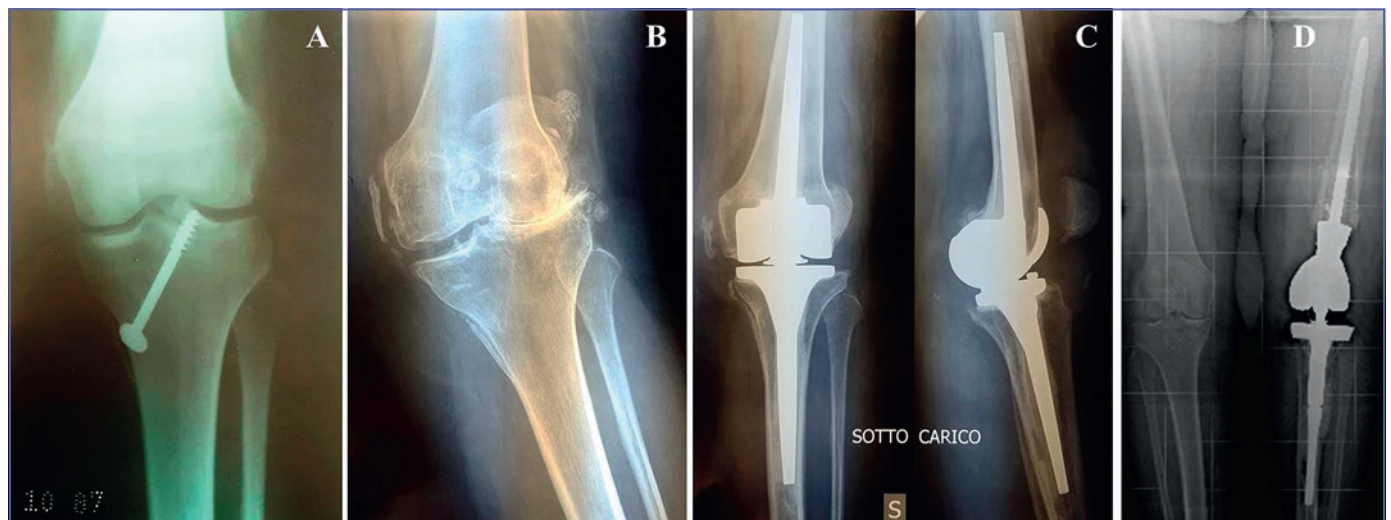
x-ray of previous surgeries. A) tibial plateau osteosynthesis (1987); B) post-traumatic osteoarthritis (2014); C) TKA with an hinged prosthesis (2015); D) TKA with a femoral megaprosthesis after a staged revision for infection (2017). TKA: total knee arthroplasty
